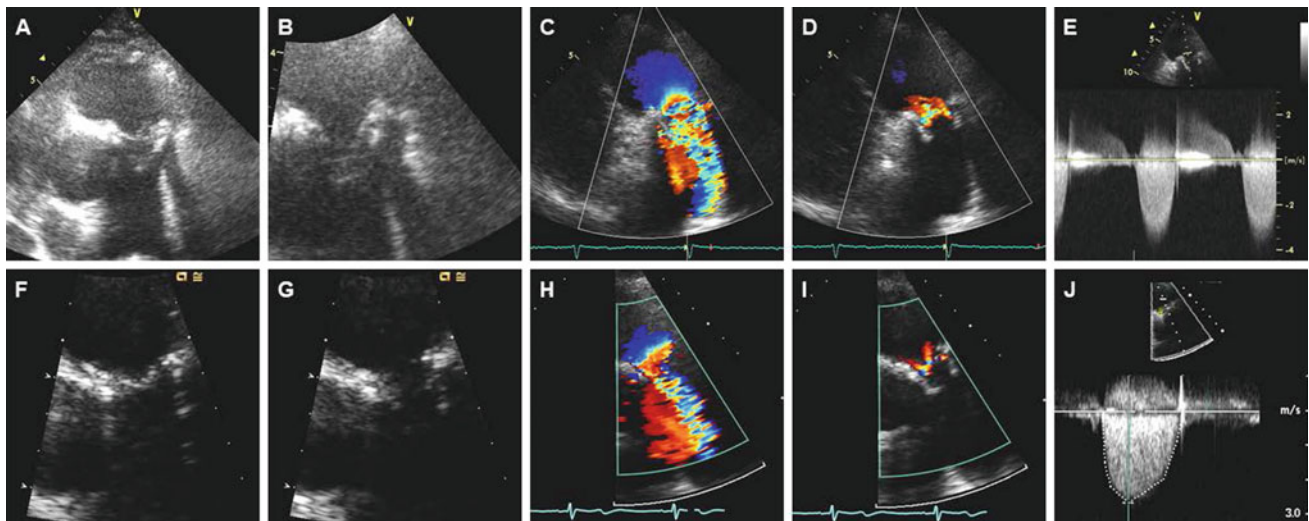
Pulmonary valve bioprosthesis obstruction. The leaflets of the pulmonary valve bioprosthesis appear thickened with a possible echodensity representing pannus or thrombus on the ventricular aspect of the anterior leaflet seen during diastole (A). During systole, the leaflets appear restricted while in the open position (B). Color Doppler shows prominent flow acceleration across the bioprosthesis during systole suggesting significant obstruction (C). There is only mild prosthetic
